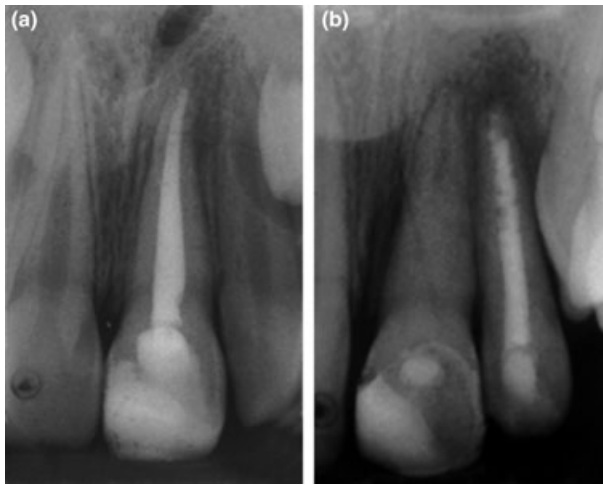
Periapical radiographs showing examples of adequate (a) and inadequate (b) obturation of the root canal of permanent incisors.
